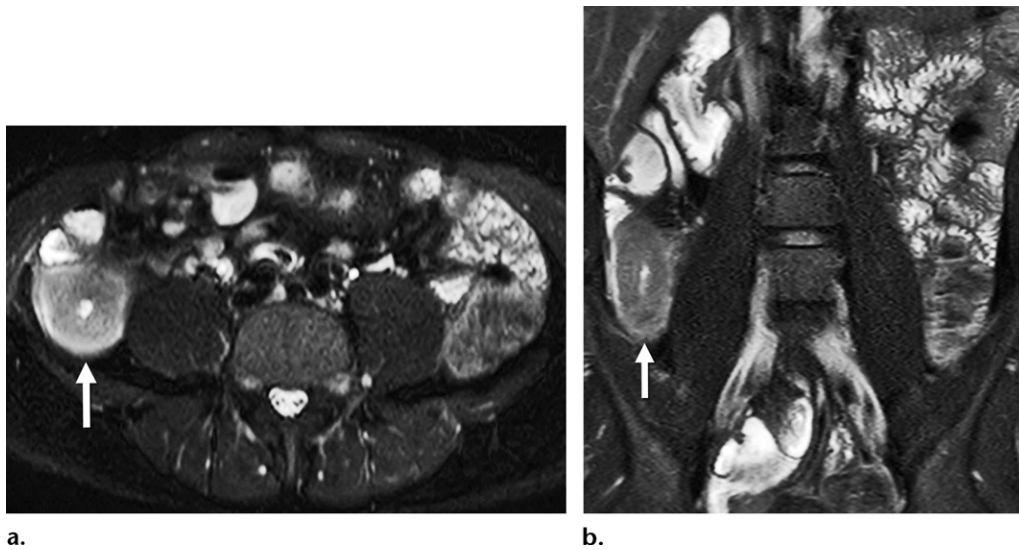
Severe wall thickening (≥ 10 mm). Axial (a) and coronal (b) fat-suppressed T2-weighted MR enterographic images with biphasic oral contrast material show severe small bowel wall thickening, mural edema (hyperintense mural signal intensity compared with that of the adjacent psoas muscle or normal bowel wall), luminal narrowing, and perienteric edema, findings consistent with active inflammatory Crohn disease with luminal narrowing (arrow).
